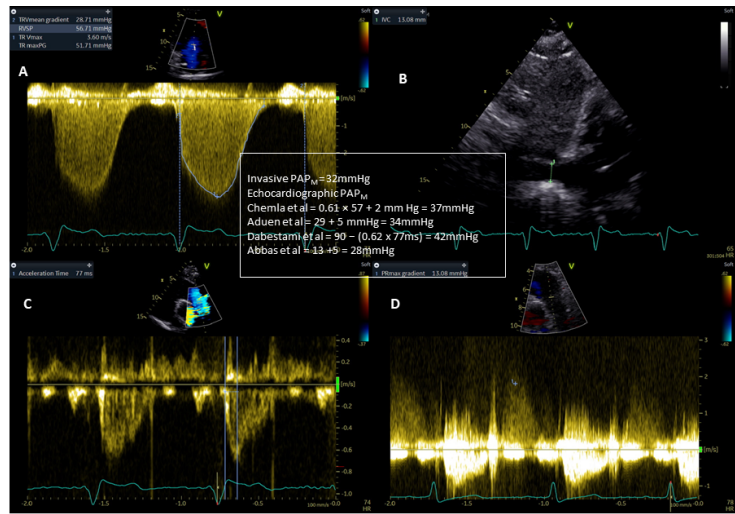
Echocardiographic evaluation of PAP_w. A) CW Doppler spectrum of TR velocity for TRVmax (Chemla et al) and TR mean gradient (Aduen et al). B) IVC size and collapse to estimate RAP (Chemla et al, Aduen et al, Abbas et al). C) RVOT acceleration time assessed by PW Doppler (Dabestani et al). D) PR peak gradient assessed by CW Doppler (Abbas et al). Corresponding values of PAP_w in a subject with invasive PAP_w = 32 mmHg provided.
